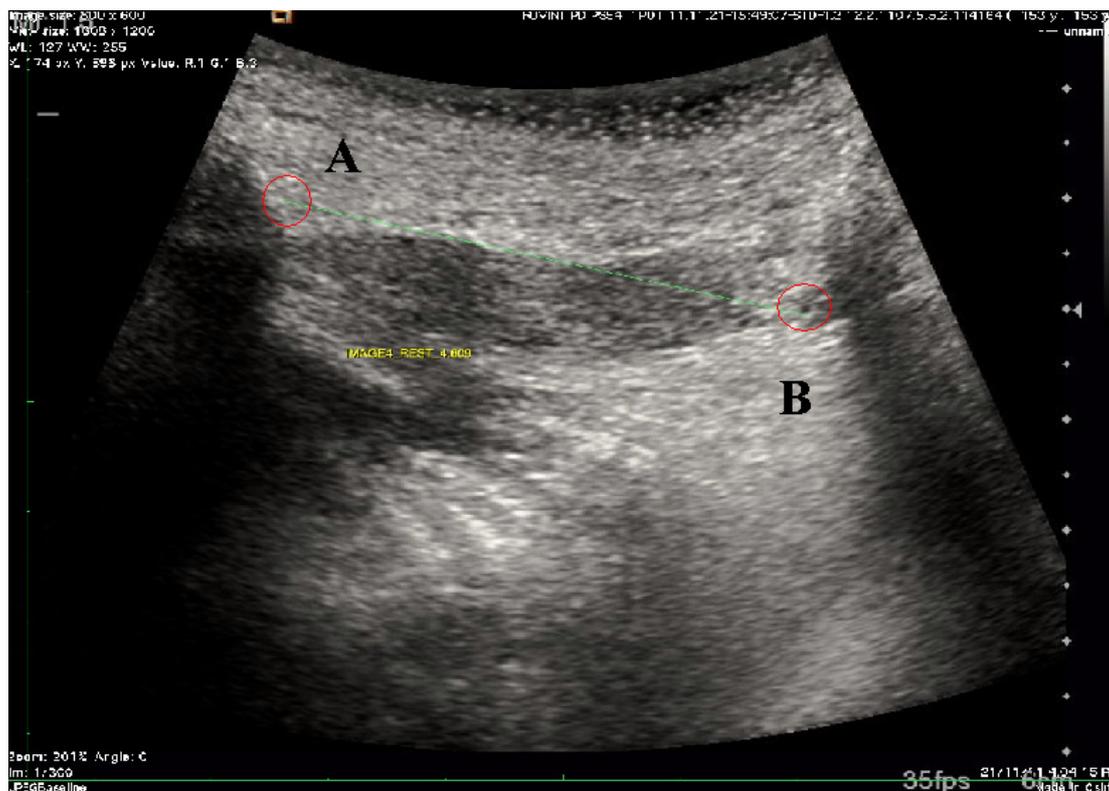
B mode ultrasound image of the hyoid and spine of mandible distance at rest. Electronic calipers mark the points at which the distance between mental spine of mandible shadow (A) and the intersection of the hyoid shadow with the geniohyoid muscle (B).
